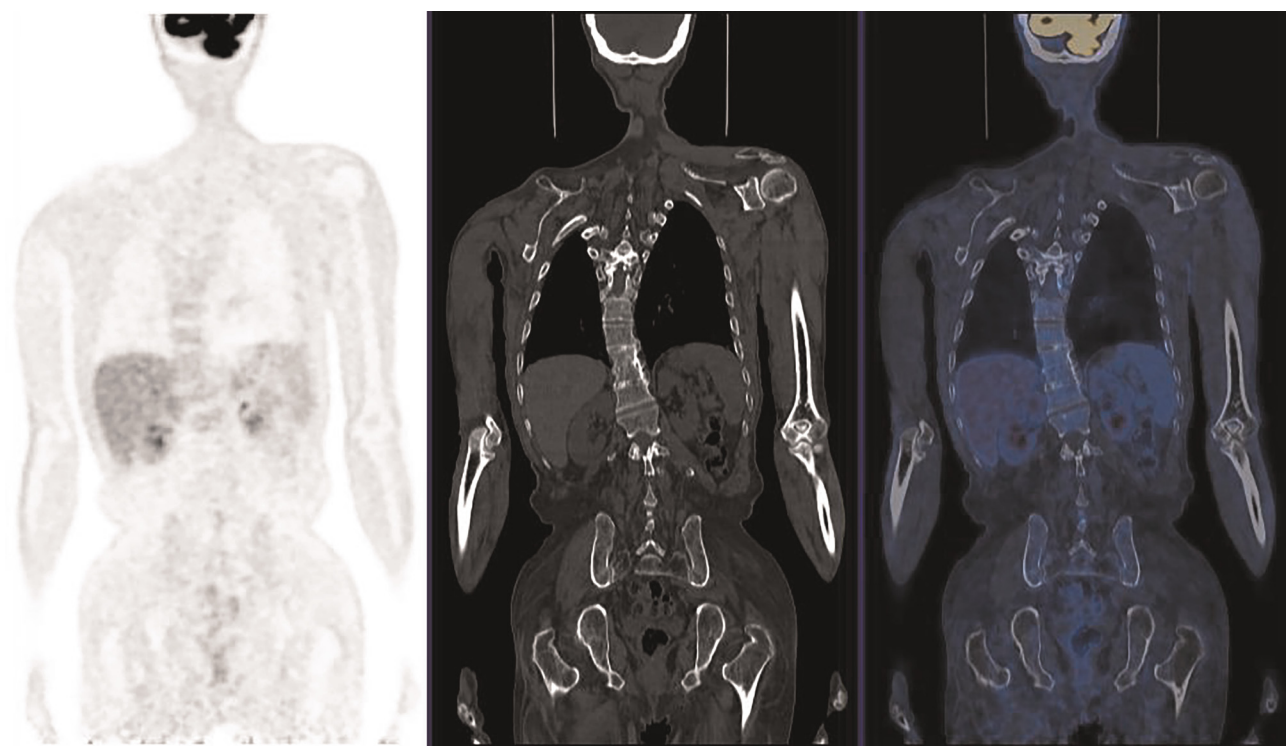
The PET-CT whole-body scan of the patient. It revealed multiple instances of muscle atrophy without any accompanying pathological abnormalities in FDG uptake, ruling out the possibility of inflammatory or neoplastic lesions.
